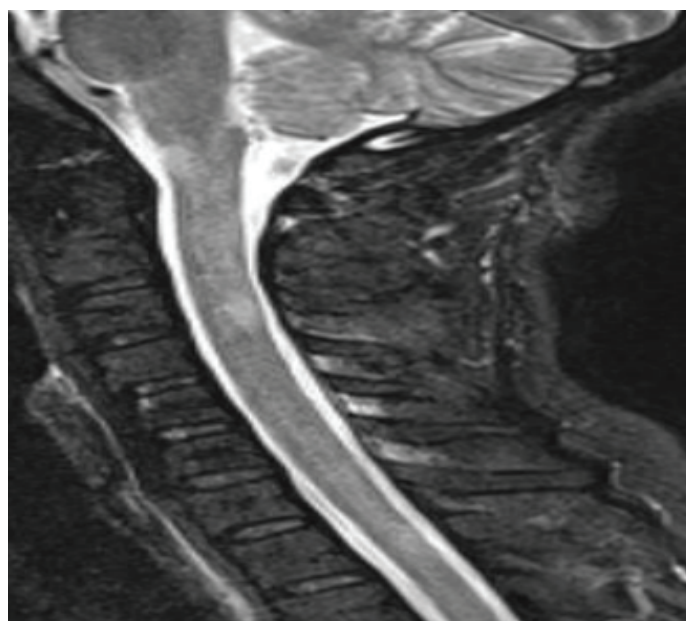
Demyelinating plaques on servical magnetic resonance imaging. Sagittal section image with T2 FLAIR
